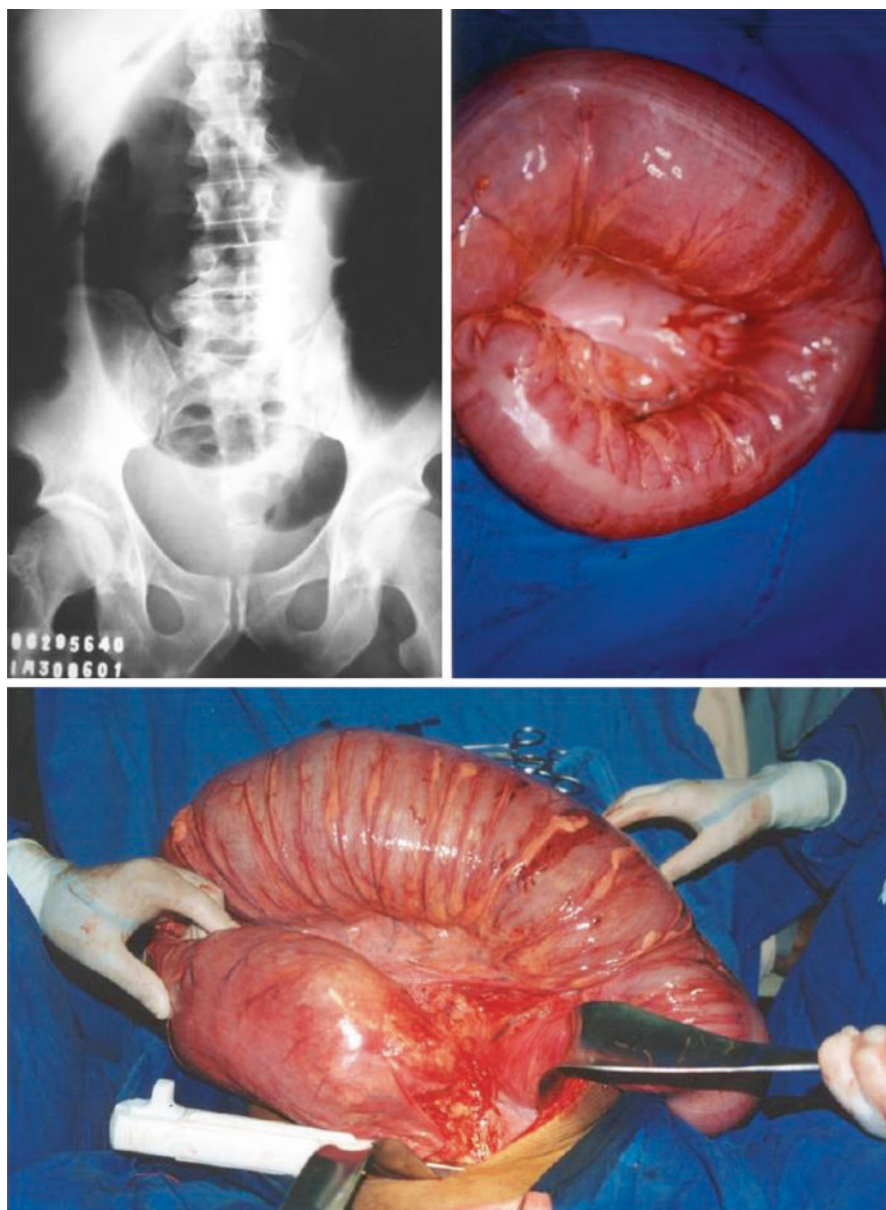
Sigmoid volvulus: abdominal plain X-ray and surgical treatment. Pictures courtesy of Dr. Ê. Chaves de Oliveira
